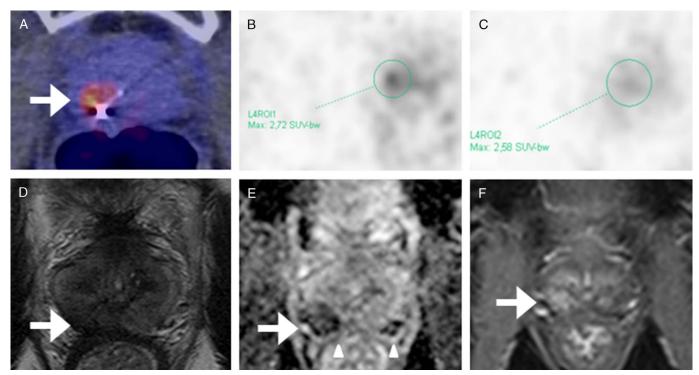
A 77-year-old man with biochemical recurrence (PSA 3.0 ng/mL) after EBRT. On axial ⁶⁸Ga-PSMA PET/CT (A), focal uptake was seen (arrow); however, its SUVmax of 2.72 (B) was hardly different (approximately 5%) from background noise with an SUVmax of 2.58 (C). Therefore, it was prospectively called negative for local recurrence. ⁶⁸Ga-PSMA PET/CT suggested only 1 suspicious lymph node in the right obturator area (not shown). Multiparametric MRI (performed 6 days later) showed a local recurrence in the right peripheral zone on T2-weighted (D, arrow), apparent diffusion coefficient map (E, arrow), and contrast-enhanced (F, arrow) images. Targeted MRI-TRUS fusion biopsy confirmed recurrent disease (Gleason 4 + 3). In this case, a lesion with only slight focal PSMA uptake, which was interpreted as benign, turned out to be malignant. Overlap of SUV values between malignant and benign prostate disease on ⁶⁸Ga-PSMA PET²⁻⁶ should be taken into account, and additional mpMRI should be performed.
